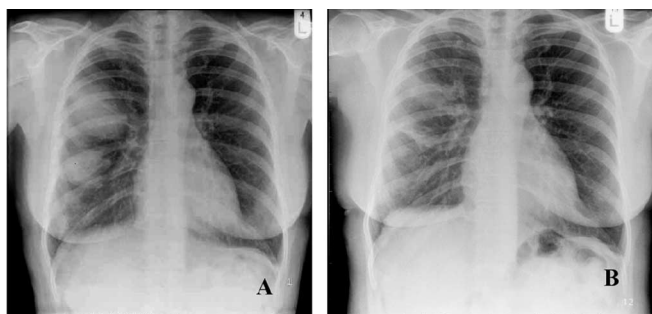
Pre-operative chest radiograph of a patient with lung carcinoma regarded inoperable at thoracotomy (A). Chest radiograph of the same patient six months after direct cryosurgery to the lung carcinoma (B).
